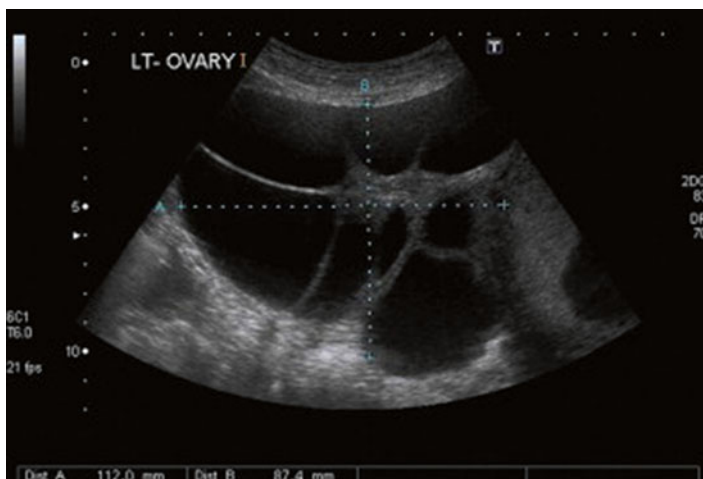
Hyperreactio luteinalis by transvaginal ultrasound, with a spoke-wheel appearance (Reprinted from Amoah et al. [14], with permission from Elsevier and the American Society of Reproductive Medicine)
